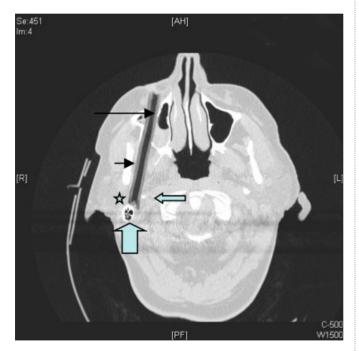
b: The location of the air-containing bamboo cane and its relationship to the maxillary antrum (long black arrow), mandibular ramus (short black arrow), mastoid tip (short block arrow), parotid (star), and styloid process (long block arrow) is well demonstrated on an oblique axial reconstruction of the unenhanced CT scan displayed on bone windows.
